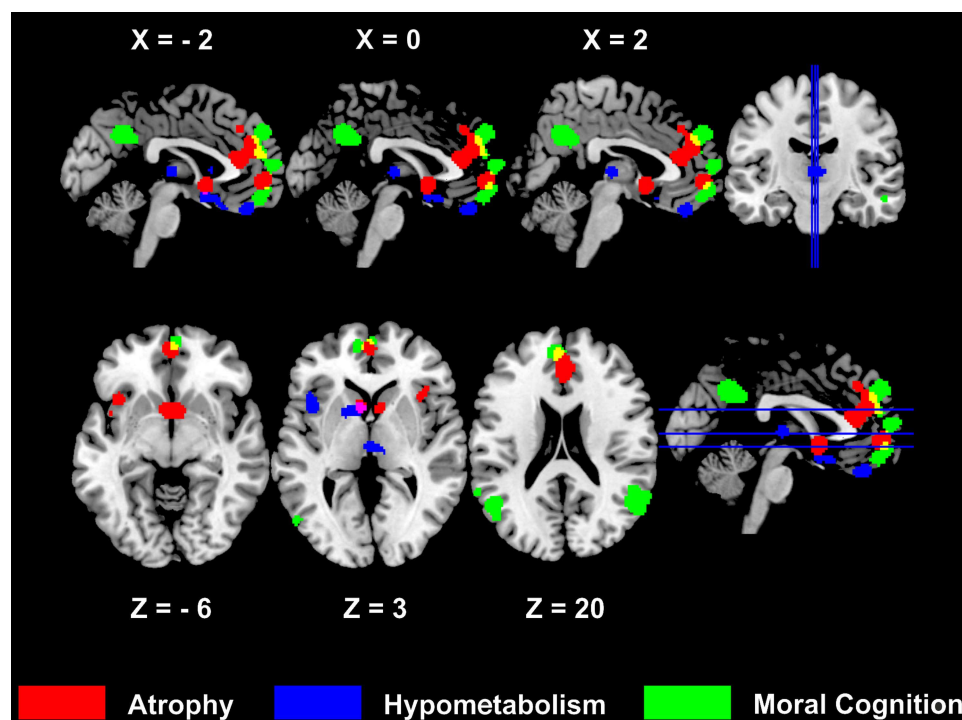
Conjunction between neural correlates of behavioural variant frontotemporal dementia (bvFTD) and of moral cognition in healthy participants. Atrophy in bvFTD as measured with MRI red, glucose hypometabolism in bvFTD as measured with 18F-fluorodeoxyglucose positron emission tomography blue, respective overlap pink. Functional neural correlates of moral cognition in healthy participants green. Overlap between atrophic brain regions in bvFTD and moral cognition networks in healthy participants yellow. Anatomical and functional activation likelihood estimate meta-analyses. For statistical values see refs. ³ and ⁴. Left is left. Montreal Neurological Institute (MNI) coordinates.
